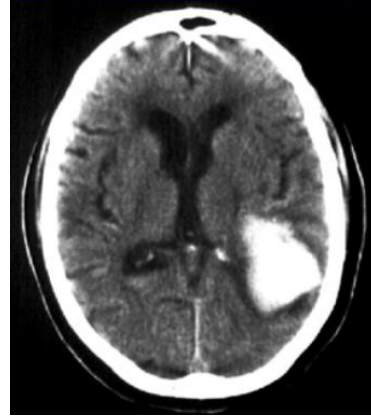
CT scan of Intraparenchymal hemorrhage Fig.12 CT scan of intraventricular hemorrhage
